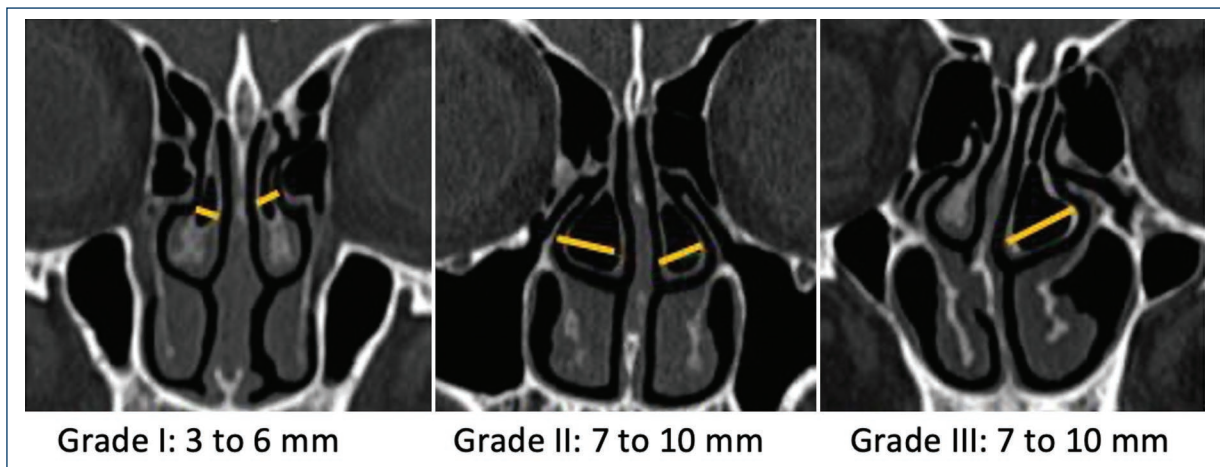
Coronal plane CT scan images showing CB types according to size (HGMEI).
